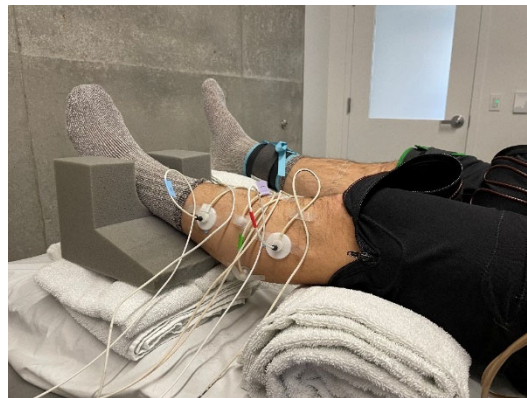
Four laser Doppler probes positioned on the skin surface of the lateral calf. The two single point probes were seated within a local heating unit. Photo by Emily Larson.
